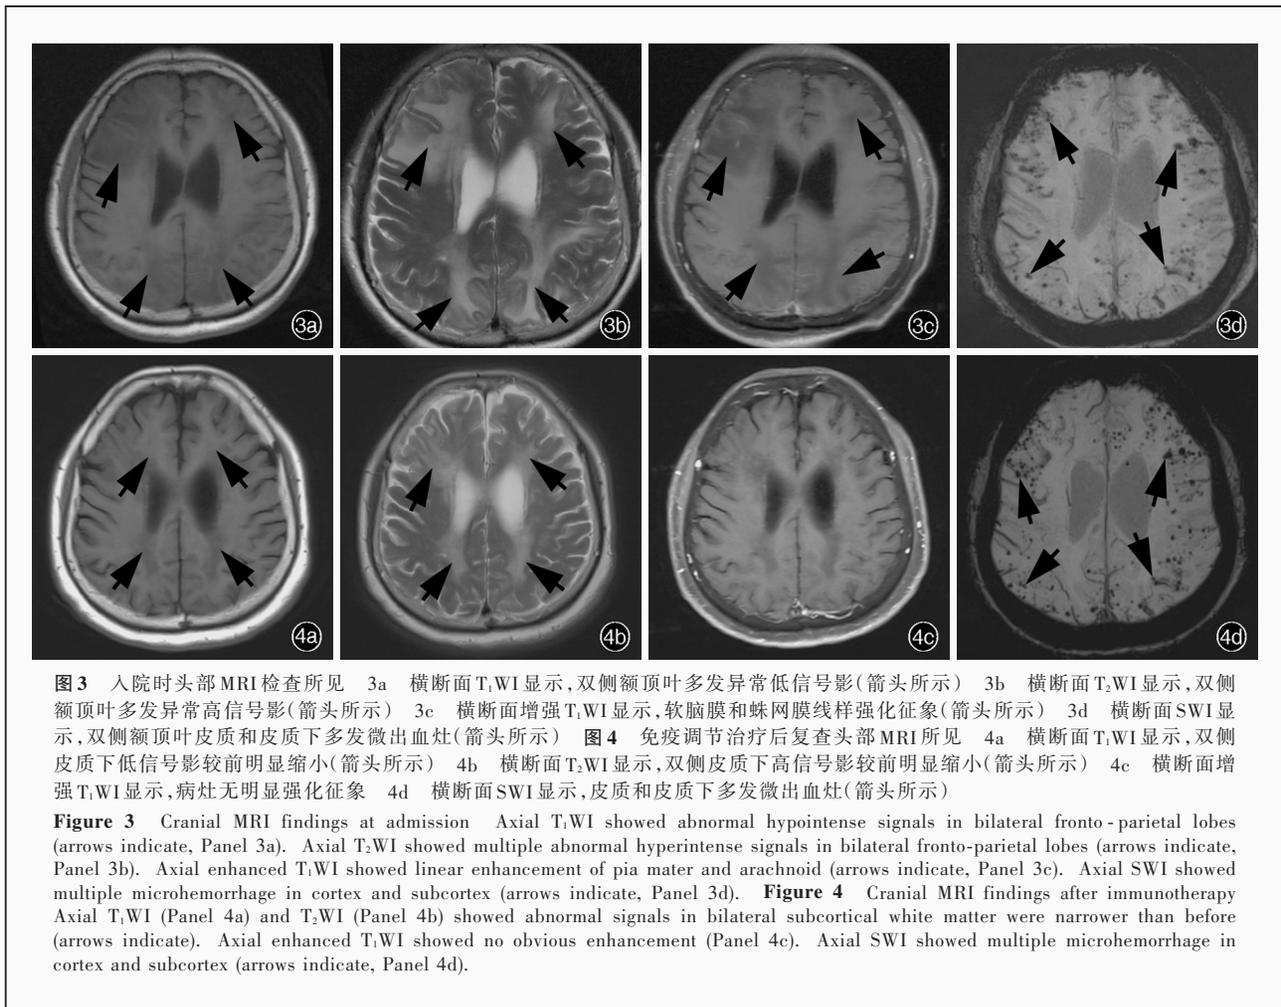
入院时头部 MRI 检查所见 3a 横断面 T₁WI 显示, 双侧额顶叶多发异常低信号影(箭头所示) 3b 横断面 T₂WI 显示, 双侧额顶叶多发异常高信号影(箭头所示) 3c 横断面增强 T₁WI 显示, 软脑膜和蛛网膜线样强化征象(箭头所示) 3d 横断面 SWI 显示, 双侧额顶叶皮质和皮质下多发微出血灶(箭头所示) 图 4 免疫调节治疗后复查头部 MRI 所见 4a 横断面 T₁WI 显示, 双侧皮质下低信号影较前明显缩小(箭头所示) 4b 横断面 T₂WI 显示, 双侧皮质下高信号影较前明显缩小(箭头所示) 4c 横断面增强 T₁WI 显示, 病灶无明显强化征象 4d 横断面 SWI 显示, 皮质和皮质下多发微出血灶(箭头所示)
